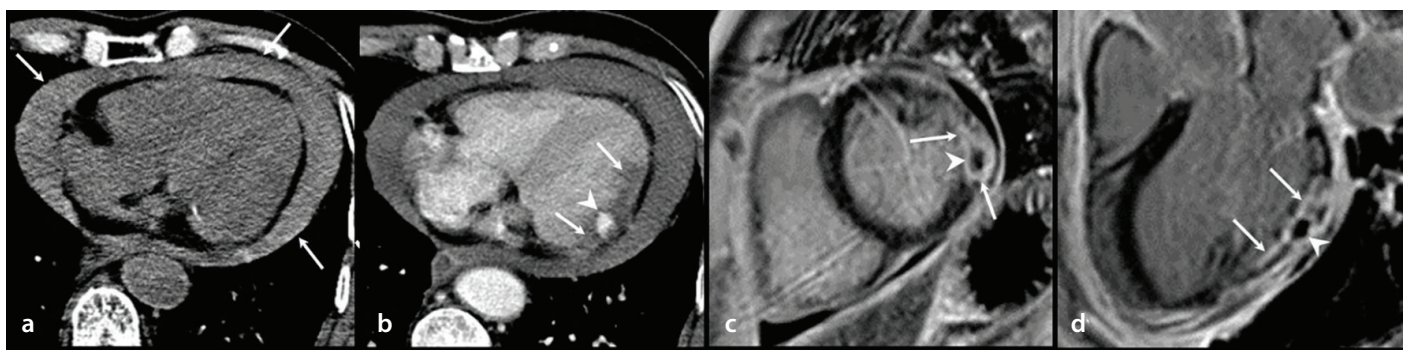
Post-MI LV free wall rupture in a 79-year-old man with NSTEMI. (a): Non-contrast axial CT image shows massive acute hemopericardium (arrows). (b): Contrast-enhanced axial CT image shows a patchy, contrast-filled outpouching lesion (arrowhead) in the lateral LV wall with poor enhancement (arrows). (c, d): Short-axis (c) and three-chamber (d) LGE-CMR images show transmural delayed enhancement (arrows) with central low signal intensity (arrowheads) in the basal to mid-lateral LV wall. Oval-shaped low signal intensity lesion was considered a thrombus within the ruptured LV wall. The patient underwent open-heart surgery, and an LV free wall rupture of the oozing type was noted in the inferolateral LV wall. NSTEMI, non-ST-segment elevation myocardial infarction; CT, computed tomography; LV, left ventricular; CMR, cardiac magnetic resonance; LGE, late gadolinium enhancement.
